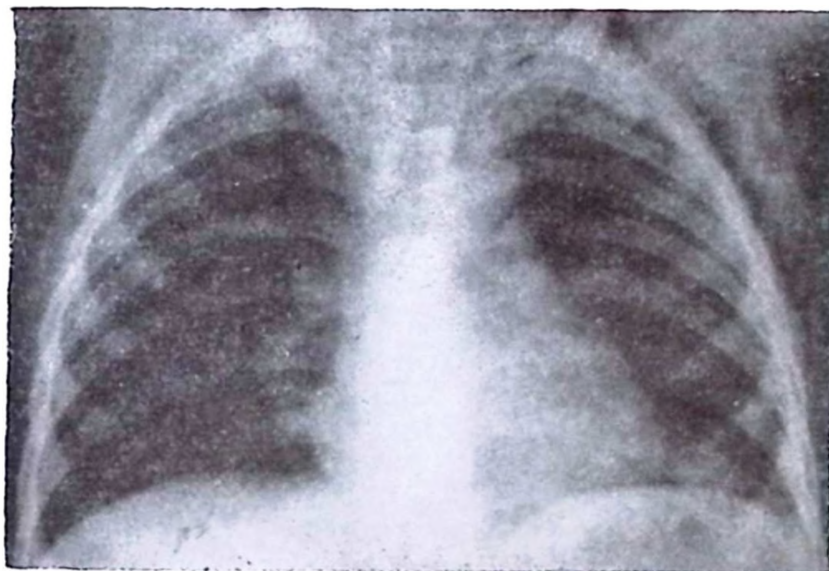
Roentgenogram of same patient showing pneumothorax on the right. 10/11/62.
